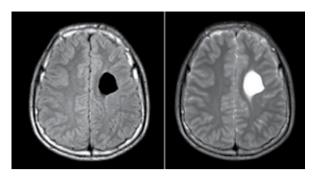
Axial cut of brain MRI suggesting that the cyst contains cerebrospinal fluid; hypointense in T1WI (right) and hyperintense in T2WI (left)
